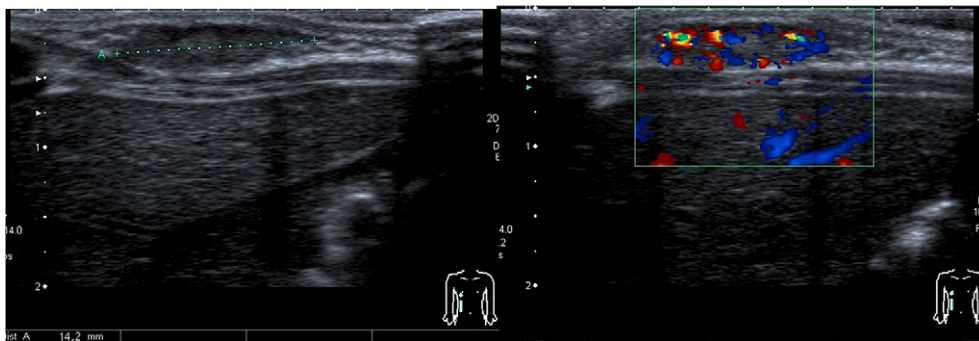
Grey-scale imaging showing a well-defined, hypoechoic lesion. This is hypervascular on Doppler and was later confirmed to be a haemangioma.
